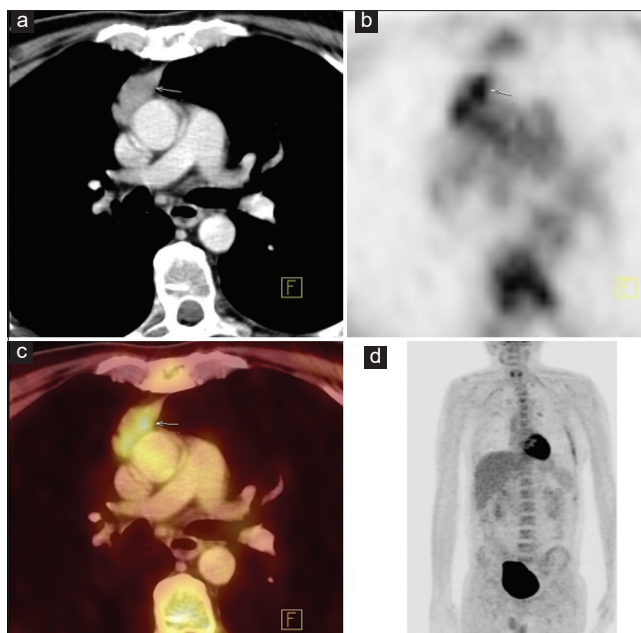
Axial computed tomography (a), axial positron emission tomography (b), axial fused positron emission tomography/computed tomography (c), Maximum intensity projection (d) F-18 fluorodeoxyglucose positron emission tomography/computed tomography showing soft tissue lesion in anterior mediastinum with mild uptake (SUVmax-4) suggesting thymoma
